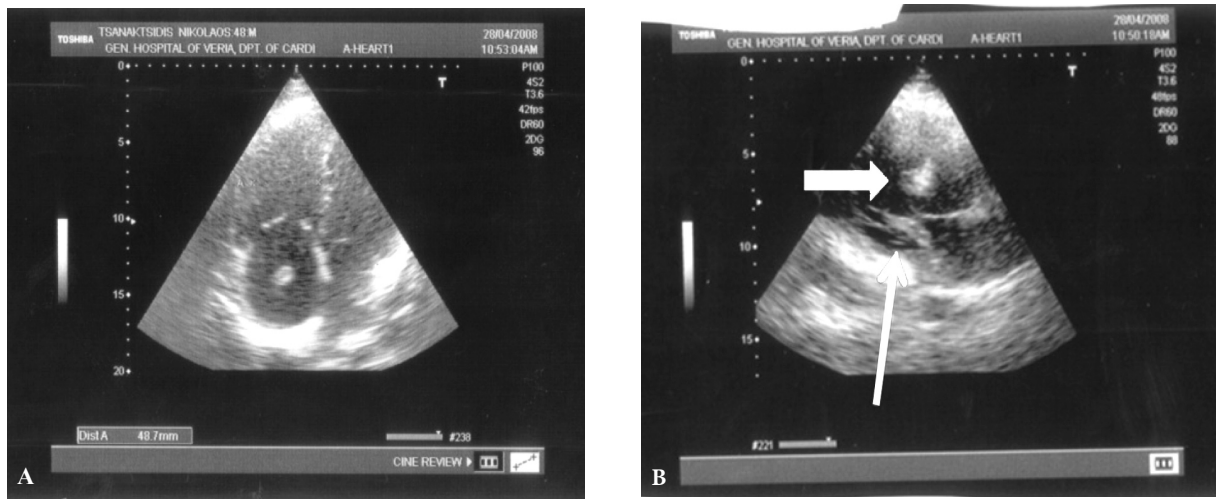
Transthoracic echocardiography in patient with right sided heart thrombi before thrombolysis. (A) Transthoracic four chamber view with thrombi in right atrium. (B) Transthoracic short axis view revealed worm-like thrombi of right ventricle (arrows).
